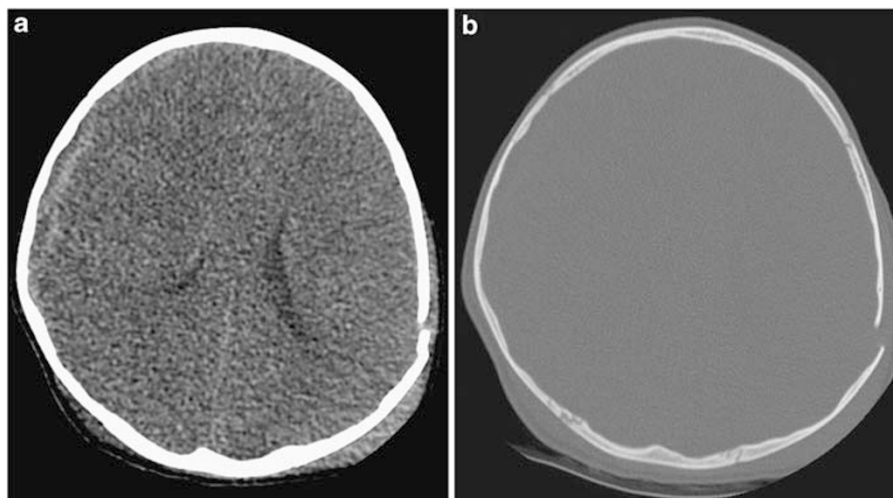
Computed tomography scan performed on day 1 of admission at the local hospital. (a) There is evidence of acute right SDH measuring 7 mm in width, midline shift, dilatation of the left lateral ventricle, and widespread cerebral oedema. (b) Bone windows showing the large left parietal fracture.
